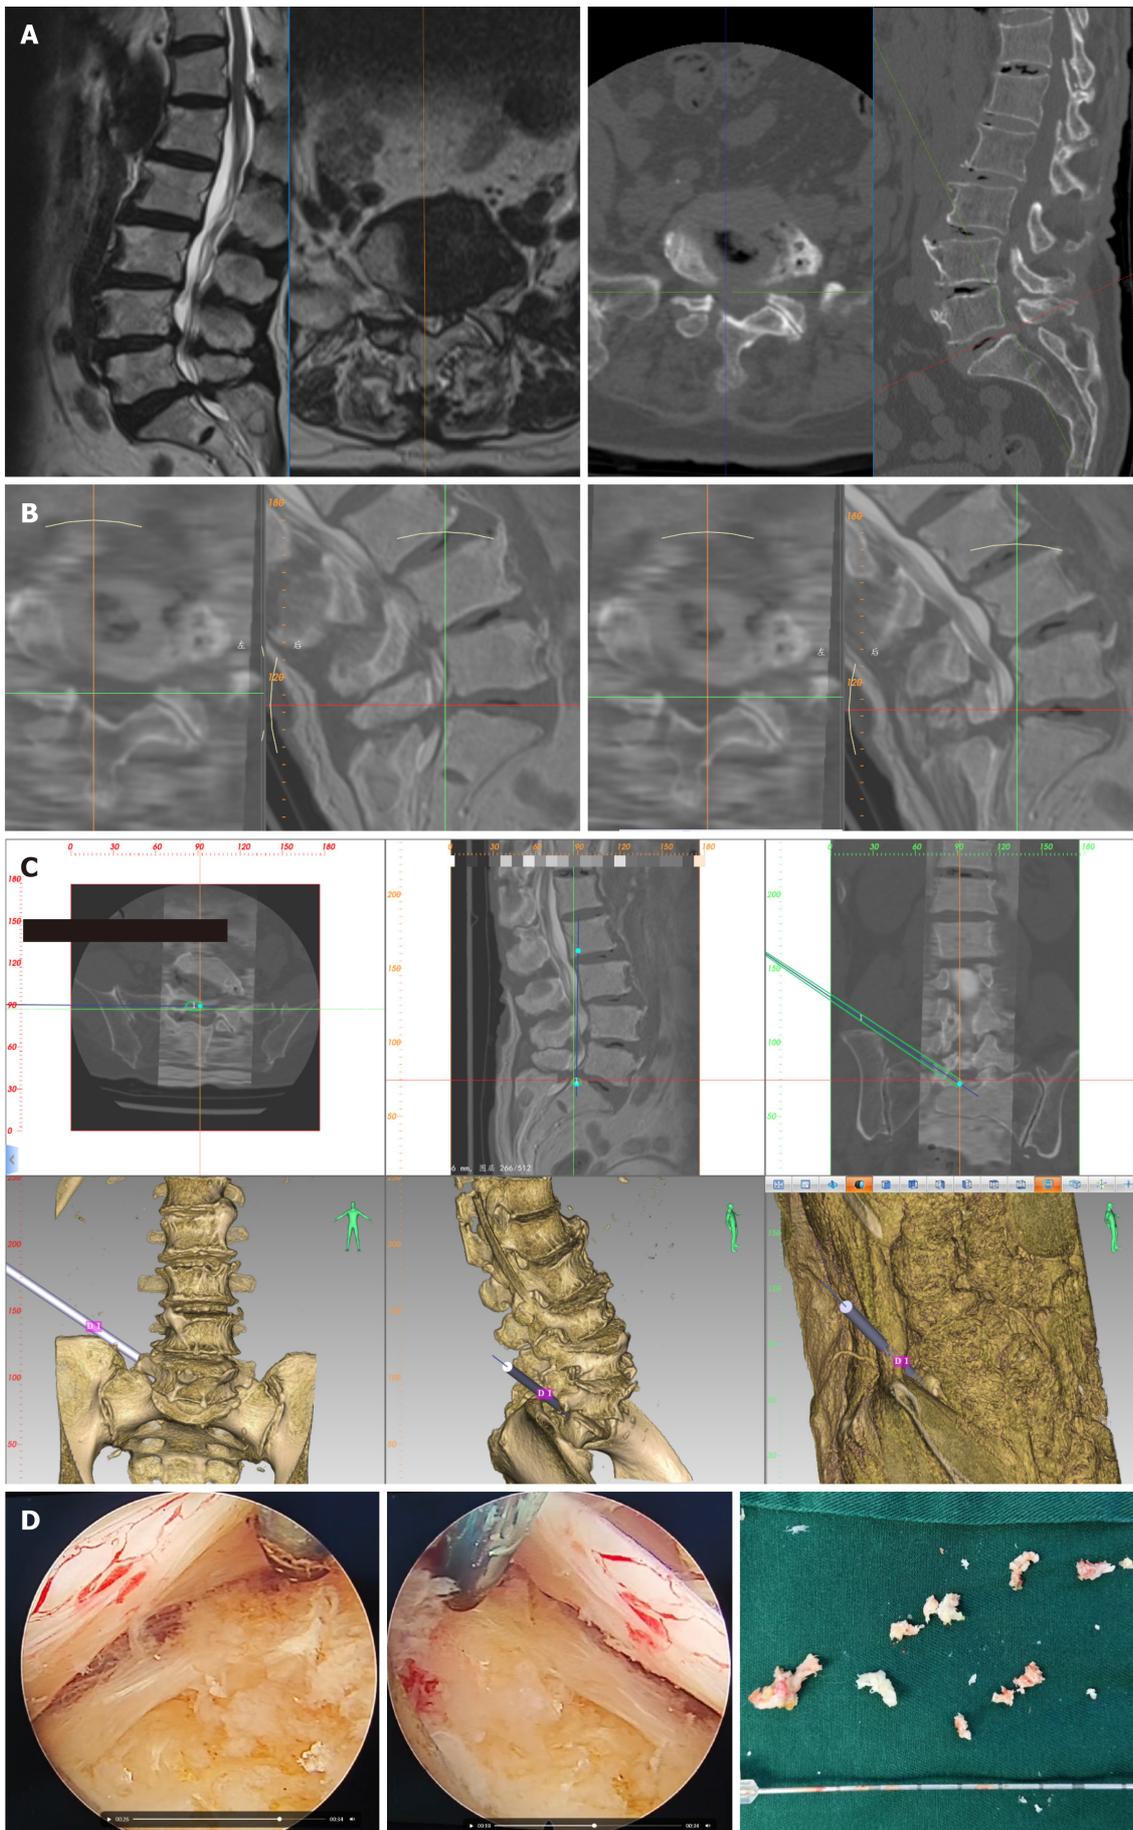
Typical case 1. A: Magnetic resonance imaging and computed tomography images showing lumbar spine stenosis (L5/S1); B: Computed tomography
